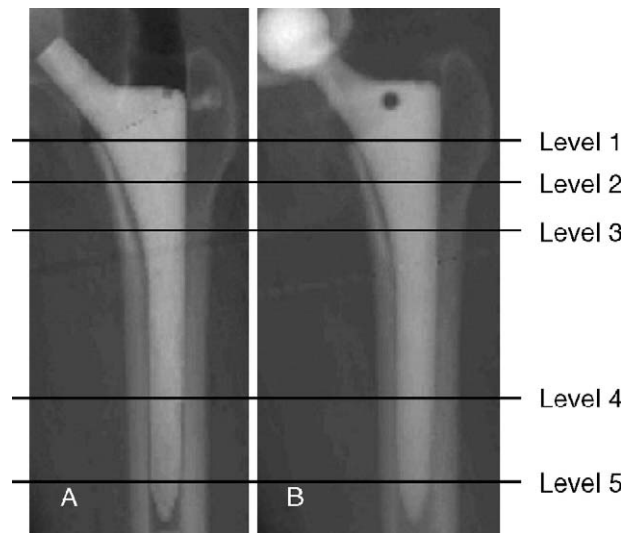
The 5 lines indicate levels 1 to 5. A, Anteroposterior synthetic radiograph from preoperative planning. B, Anteroposterior synthetic radiograph reconstructed from postoperative CT data.
